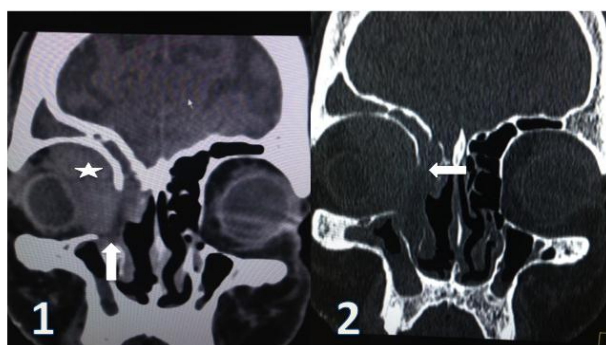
Coronal CT section (soft tissue window) of the orbit shows a soft tissue density lesion (marked by star) on the medial aspect of right orbit in the region of lacrimal sac and medial rectus muscle and seen extending up to inferior nasal cavity and maxillary ostium (marked by block white arrow)
